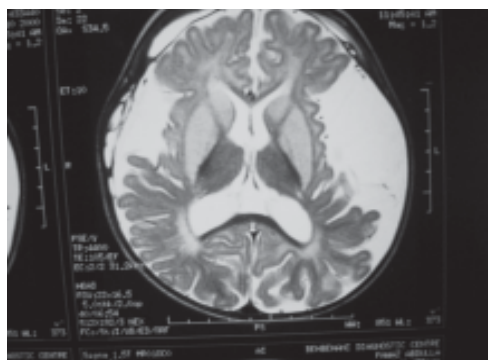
Magnetic resonance imaging scans of the head shows fronto-temporal atrophy and bilateral subdural haemorrhage
